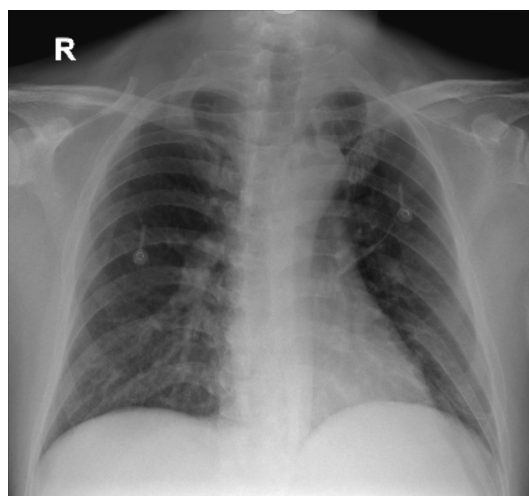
Chest x-ray of the patient showed bilateral lower lobe pneumonia.
